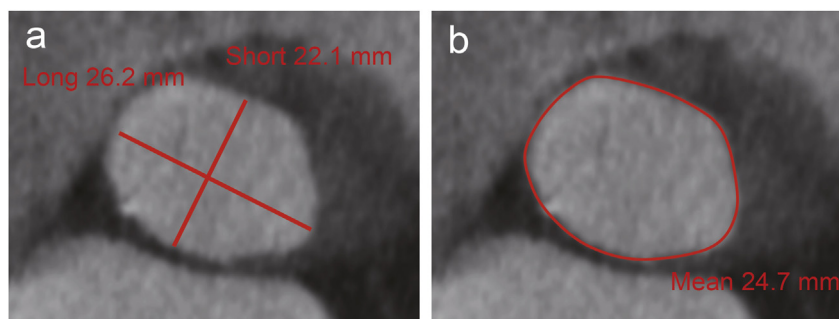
Measurement of an aortic annulus on multidetector computed tomography: (a) the short-axis and long-axis diameter were measured as mm and mm, respectively and (b) mean-diameter was calculated as mm based on the formula: $\text{mean Diam-CT} = 2\sqrt{(\text{annulus surface area}/\pi)}$.
